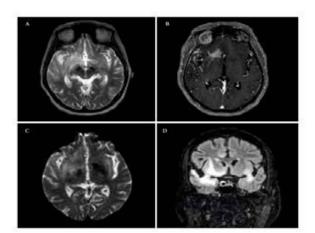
Initial MRI scans of the brain. (a) Axial T2 showing high signal in the right temporal lobe. (b) Axial post-contrast scan, demonstrating an area of contrast enhancement in the right temporal lobe. (c) Axial DWI, depicting a similar area of high signal in the right temporal lobe. (d) Coronal FLAIR with high signal in both temporal lobes and extending to basal ganglia bilaterally.
